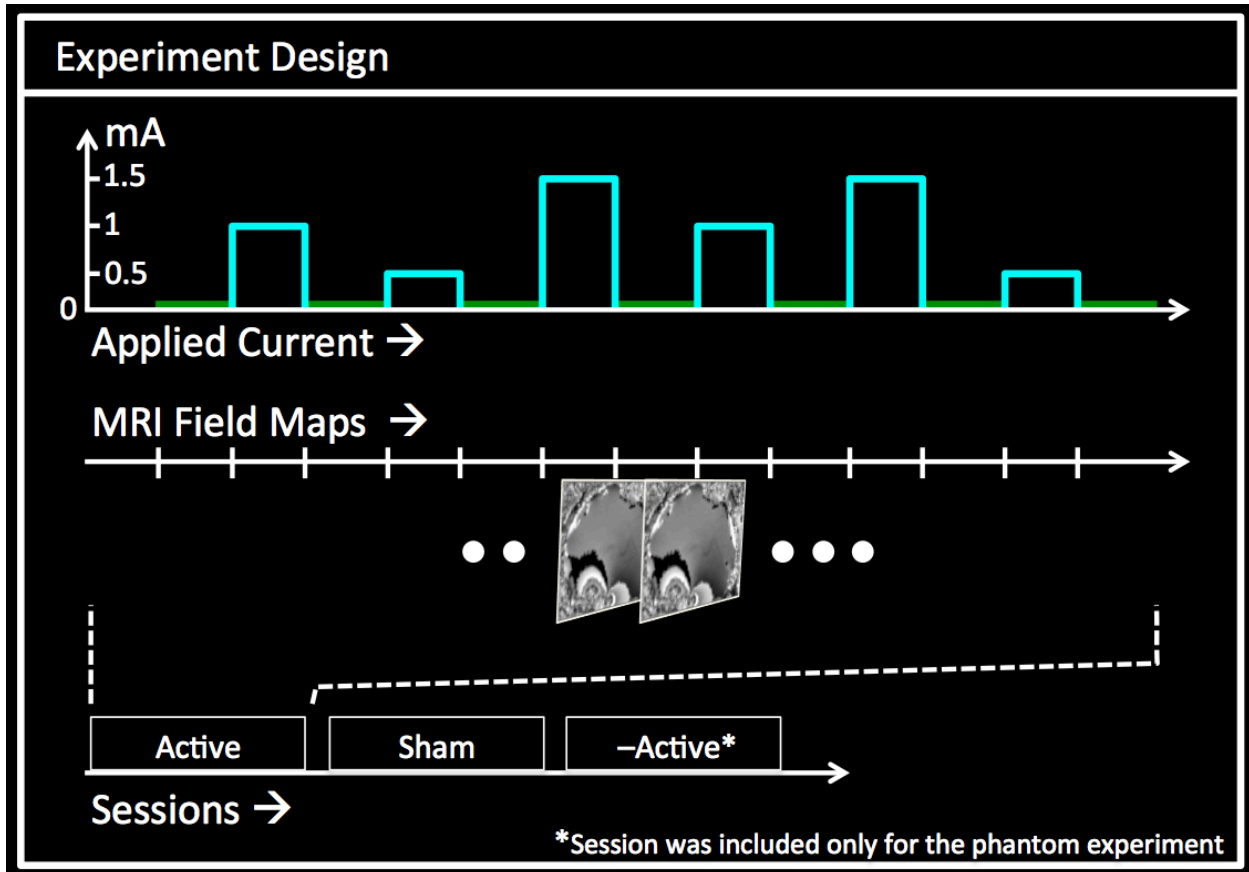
Experiment design and the MRI protocol for the “#1” implementation: Each MRI session consisted of 3 currents (repeated twice) and concurrent field mapping scans. Currents were applied in a pseudo random order, and interleaved with zero current scans. In the ‘Sham’/ ‘–Active’ sessions, the electric current was turned off/ was applied with reversed polarity, respectively.
